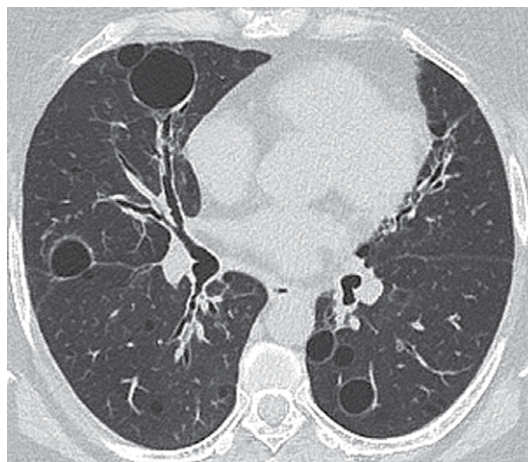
Axial reconstruction of a CT scan of a female patient with follicular bronchiolitis. Note the thin-walled cysts of various diameters throughout the lung parenchyma, especially along the peribronchovascular bundle.
